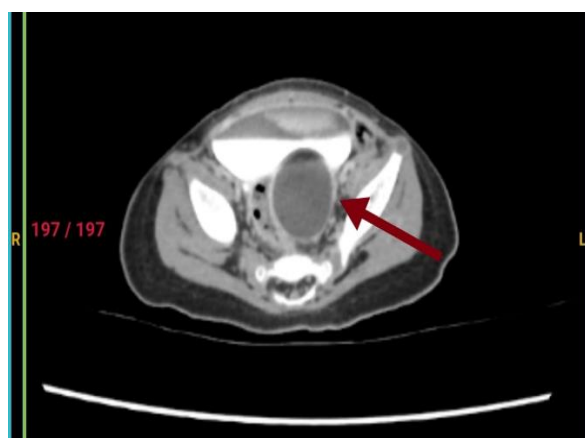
CT urography showing the gross dilatation of left ureter with contrast draining in to bladder from right kidney.
